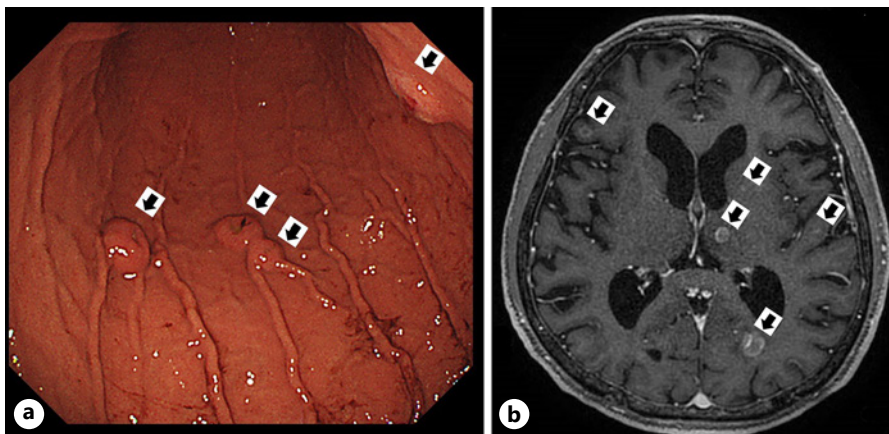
Multiple metastases. a EGDS shows multiple gastric metastases (arrow) resembling submucosal tumors in the gastric body. b Contrast-enhanced MRI of the head shows multiple brain metastases (arrow). EGDS, esophagogastroduodenoscopy; MRI, magnetic resonance imaging.
